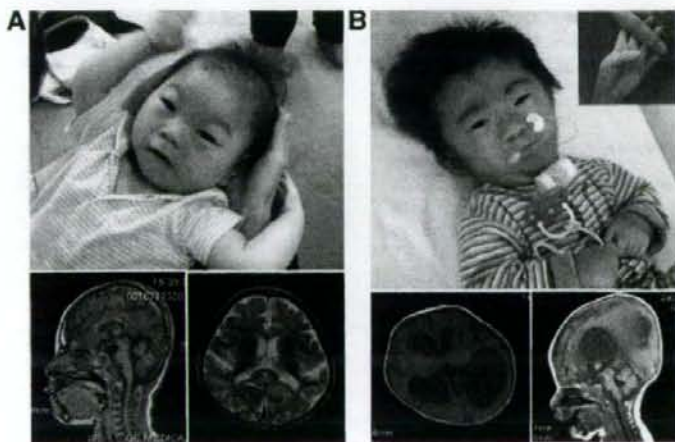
A: Patient 1. Face at 19 months (upper), and MRI images at 5 years (lower left, sagittal section; lower right, horizontal). Typical facial appearance of 1q distal deletion is seen. A simplified gyral pattern and thin corpus callosum were noted. B: Patient 2. Face at 19 months (upper) along with left hand, and MRI at 4 years (lower left, horizontal section; lower right, sagittal). Midface hypoplasia, bushy hair, and synophrys were recognized, which is rarely seen. Adducted thumb was demonstrated. MRI shows large massa intermedia and marked dilation of the lateral ventricles. Thin corpus callosum, stenosis of the Sylvius aqueduct, and mild pontocerebellar atrophy are observed.
